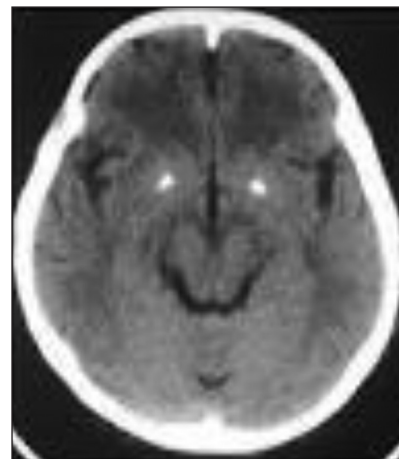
Computed tomography of head showing calcification of B/L Globus Pallidus
